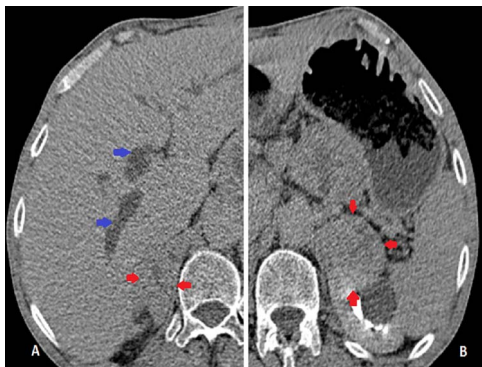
Abdominal CT scan injected (delayed phase: 10 min) in axial section (A and B) showing bilateral adrenal masses (red arrows). Note the dilatation of the bile ducts (blue arrow).
